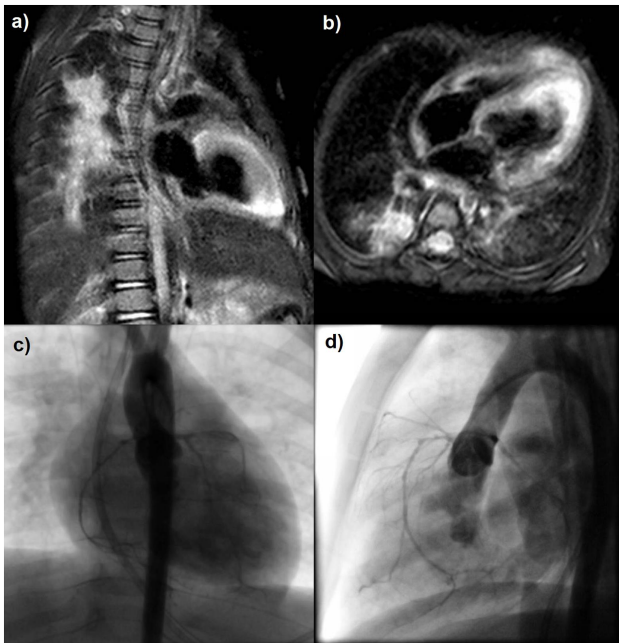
T2-weighted cardiac MRI: a) Oblique coronal plane; b) Axial plane. Coronarography: c) Posteroanterior projection; d) Lateral projection
